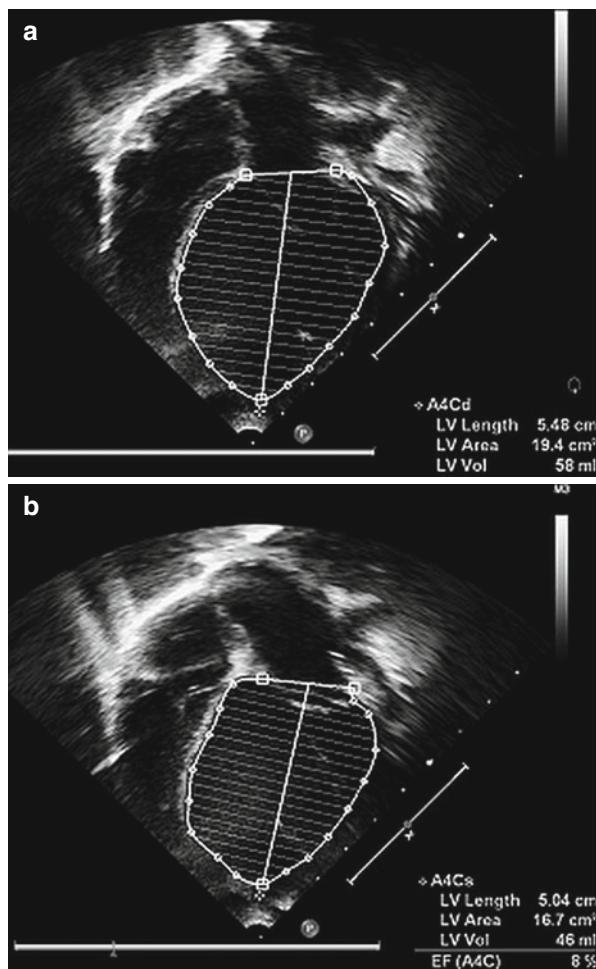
(a, b, c, d) apical four-chamber views in diastole and systole before and after rate control was established, with improvement in ejection fraction by Simpson's rule from 8 % to 25 %
